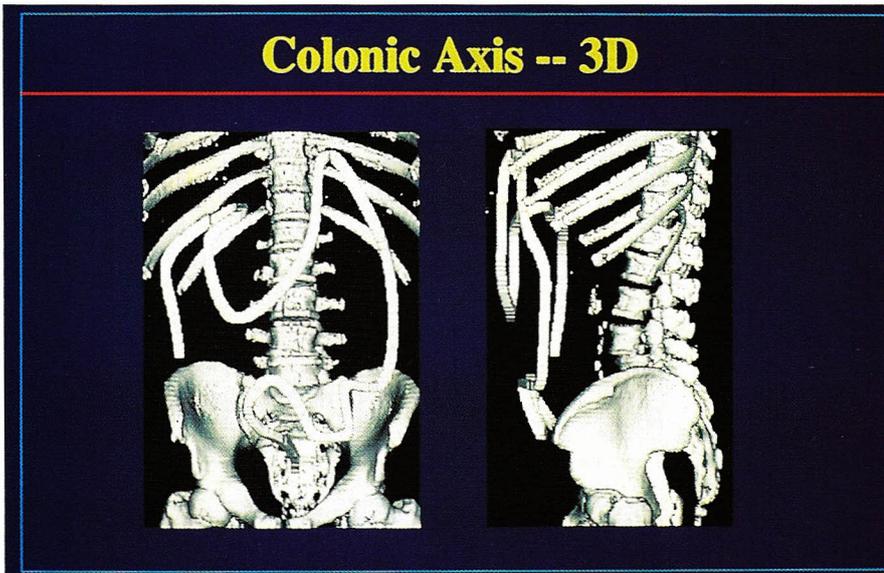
The path of the colon has been identified and fit with a spline curve. The abdominal spiral CT scan was performed in a single 30 second acquisition on a Siemens Somatom Plus S scanner.
